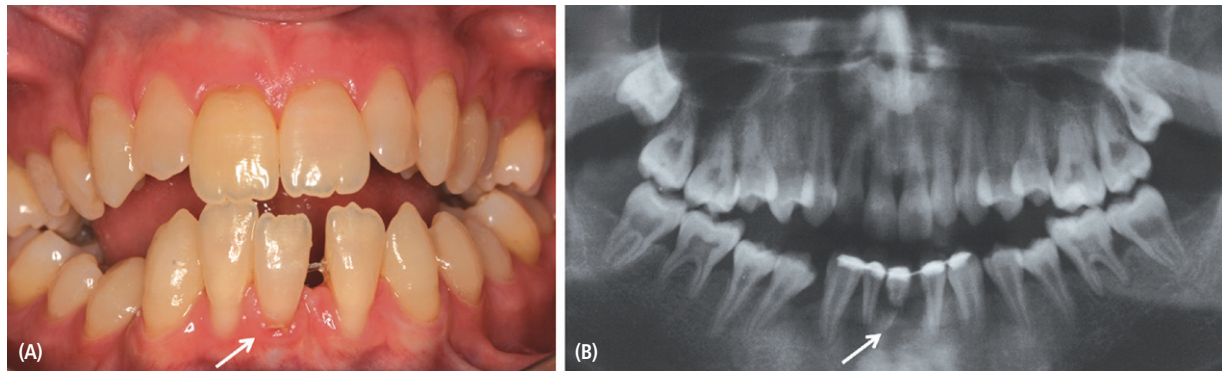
At 19 years of age, patient A suffered a fracture of the mandibular right central incisor (tooth 41) as a result of athletic trauma. A. Clinical photograph showing malocclusion and open bite. B. Corresponding panoramic radiograph displaying the fractured tooth (white arrow) and areas of reduced alveolar bone height, as well as short roots and wide pulp chambers.
